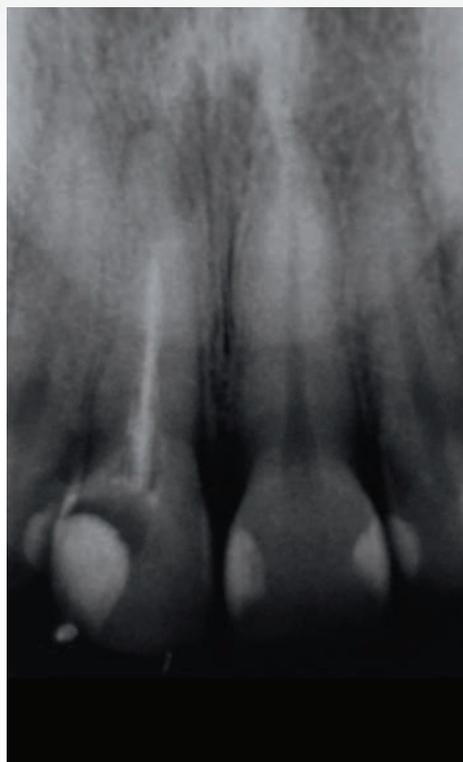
Radiographic evaluation revealed an inadequate endodontic treatment with an alteration in the periapical area.
